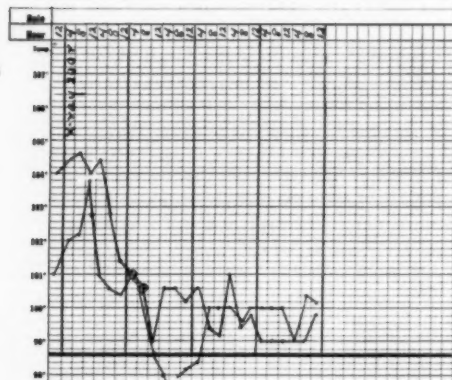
Massive lobar consolidation of right lung. Treatment with sulfonamides four days before admission to hospital. No improvement. Irradiation—200 roentgens to right anterior chest—on second hospital day, followed by rapid lysis and complete recovery.
